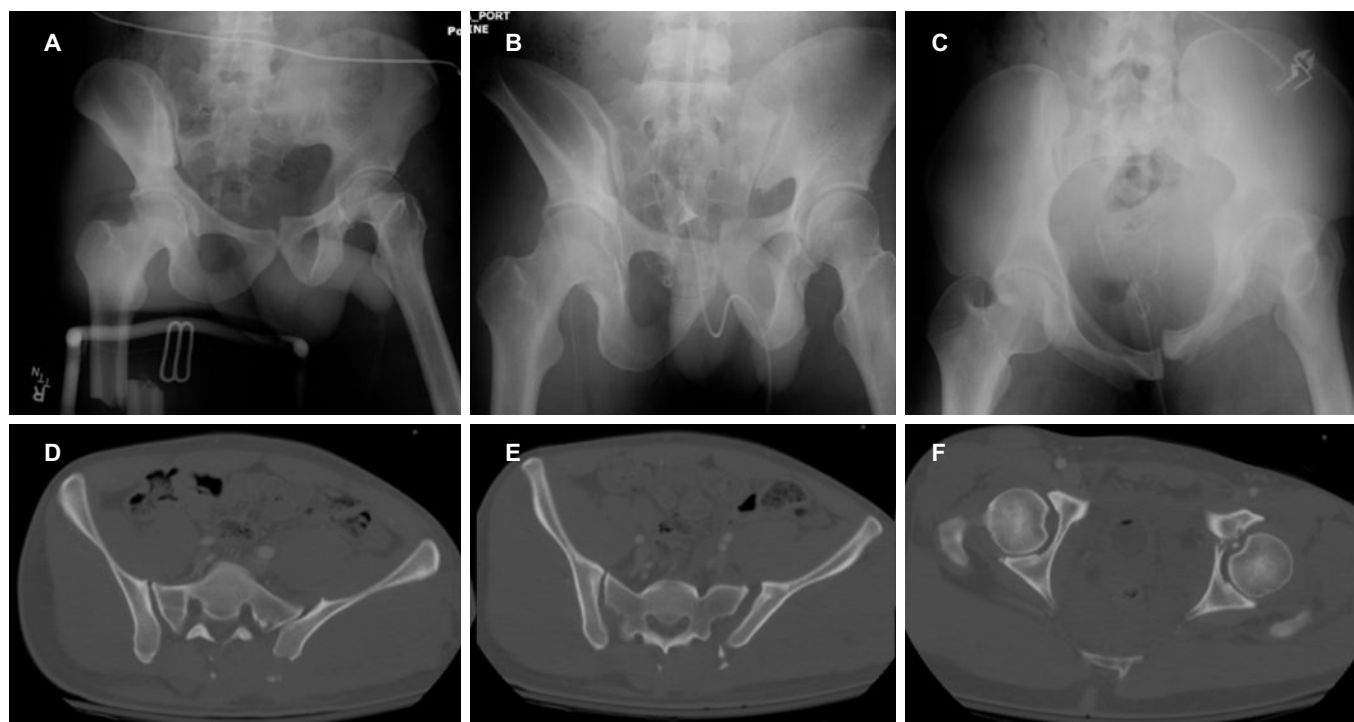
Pre-operative plain films and CT scan showing a seemingly isolated left sided injury
